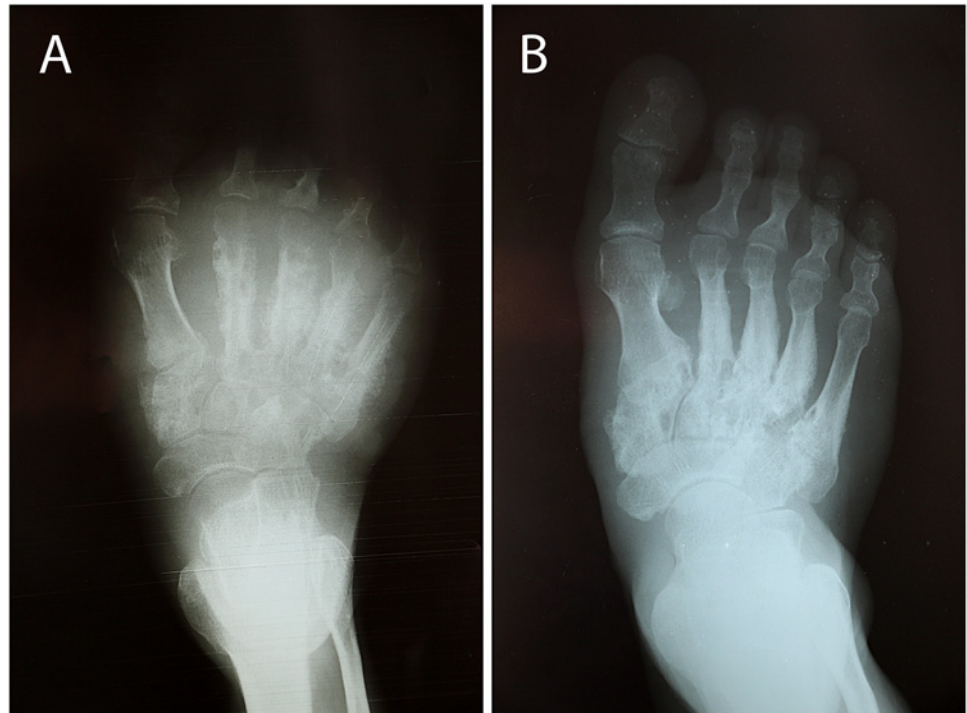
X-ray of right foot before (A) and 10 months after treatment (B).
